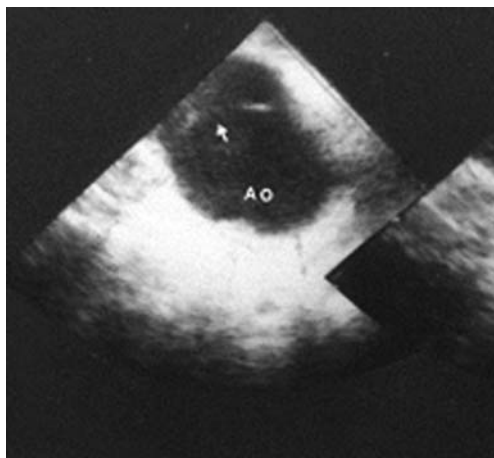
Cross-sectional transesophageal echocardiographic view of the aortic isthmus (Ao) in a patient with a partial aortic disruption following car accident. The disrupted aortic wall is mobile (arrow). Localized deformity of the posterior aortic contour is shown corresponding to the formation of acute pseudoaneurysm. Courtesy of Guido Rocchi, MD, Institute of Cardiology, University Hospital, Bologna, Italy.
